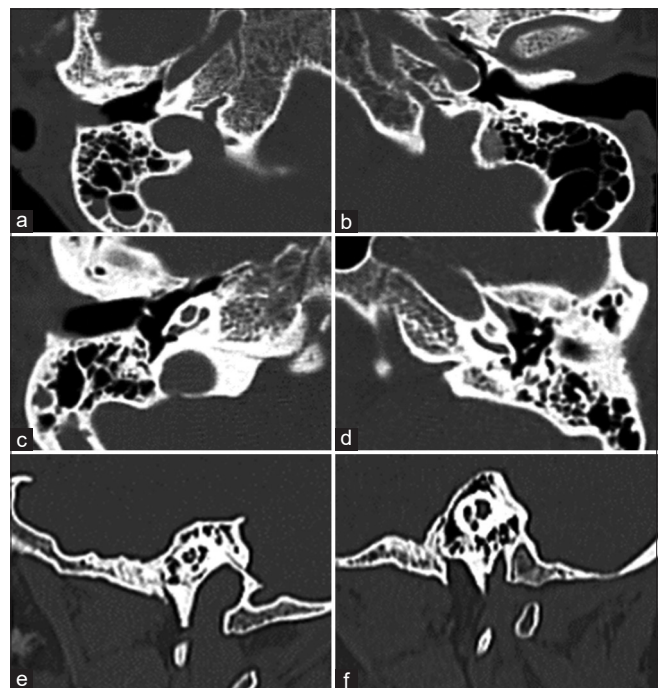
Right high riding and larger jugular bulb (JB). Case 1: High-resolution computed tomography B/L temporal bone of 25-year-old male patient. (a) Axial section: Right jugular bulb (b) Axial section: Left jugular bulb (c) Axial section: Right JB above the level of cochlea (d) Axial section: Left JB below the level of the cochlea (e) Sagittal: Right JB above the level of basal turn of cochlea (f) Sagittal: Left JB below the level of the basal turn of the cochlea
